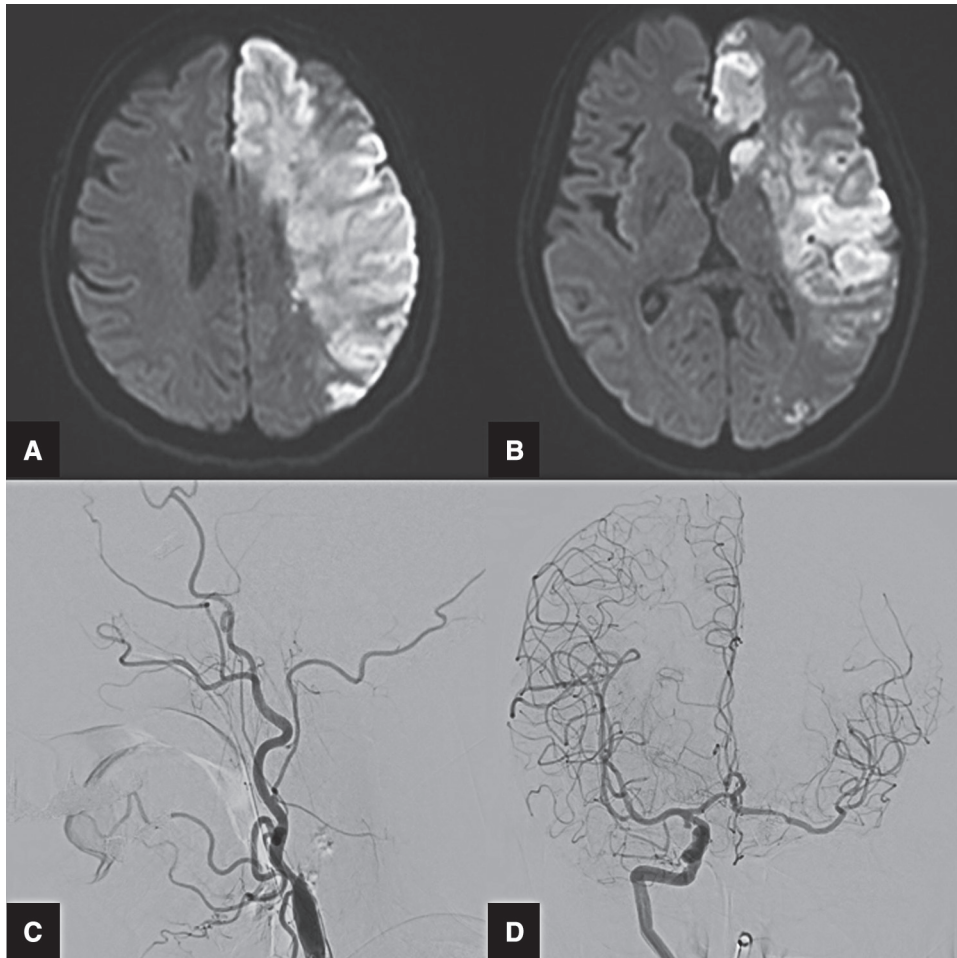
Follow-up MRI and angiography. (A and B) Postoperative day 1 DWI showed extensive hemispheric cerebral infarction of the left MCA and ACA territory. (C) Postoperative day 14 left carotid angiography revealed obliteration of the ICA. (D) Collateral flow to the left MCA via the AComA was still observed. The A2 segment of the left ACA and inferior trunk of the left MCA were obstructed as on postoperative DSA. ACA: anterior cerebral artery; AComA: anterior communicating artery; DWI: diffusion-weighted image; ICA: internal carotid artery; MCA: middle cerebral artery
